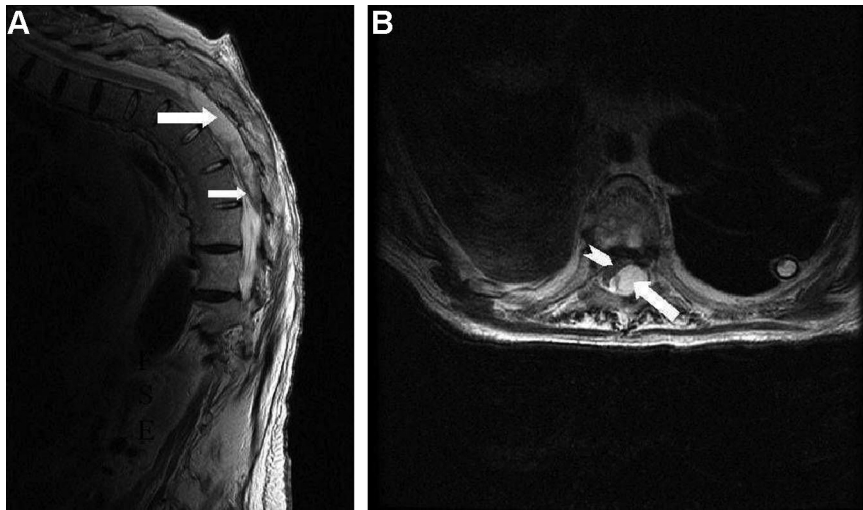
T2 weighted sagittal (a) and axial (b) magnetic resonance images depicting a large epidural mass (arrows) in the dorsal left lateral aspect of the spinal canal extending from T6 to T9 with anterolateral spinal cord displacement and compression (chevron). The epidural mass was predominantly clear fluid (i.e., cerebrospinal fluid and analgesic infusate; large arrows) with only a scant amount of blood (small arrow).
